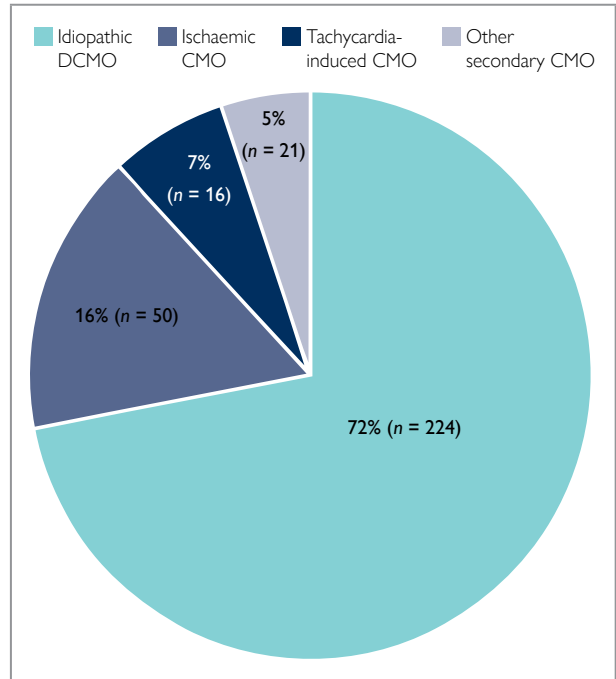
Aetiology of heart failure with reduced ejection fraction based on clinical assessment and echocardiography.
